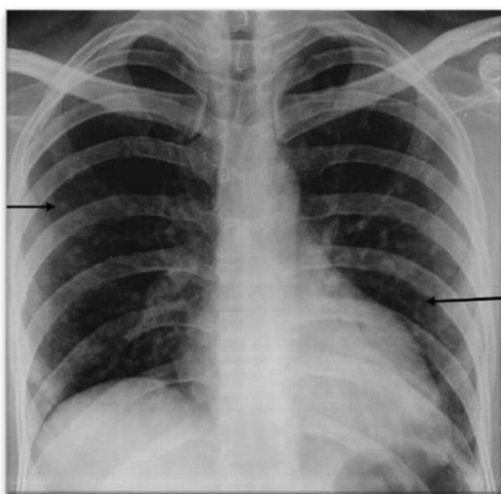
Chest X-ray showing bilateral round opacities, multiple in numbers.
